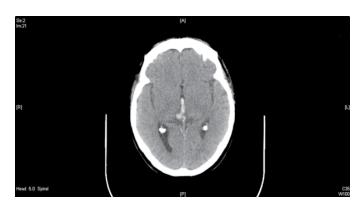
Non-contrast CT scan of head showing intraventricular extension of haemorrhage from right medial thalamic haemorrhage.
